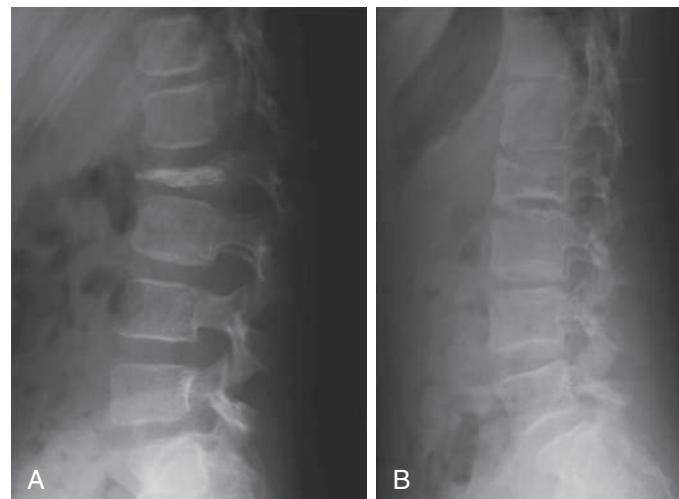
(A) Lateral radiograph of the lumbar spine of a 6-yr-old female with a painful osteolytic lesion of the L2 vertebral body with vertebral plana deformity. CT-guided frozen section biopsy showed eosinophilic granuloma; intralesional methylprednisolone injection was performed. (B) Lateral radiograph of the lumbar spine shows complete reconstitution of the lesion 7 years after diagnosis and treatment. (From Angelini A, Mavrogenis AF, Rimondi E, et al. Current concepts for diagnosis and management of eosinophilic granuloma of bone. *J Orthop Traumatol*. 2017;18:83-90. Fig. 3.)
